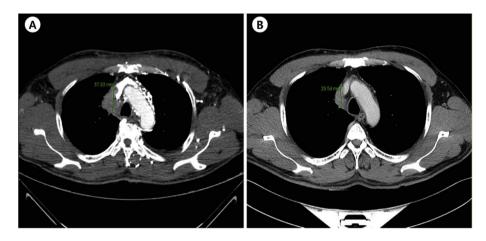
Initial lung mass in chest CT scan (A), and follow up chest CT shows interval decrease in size of the primary lung cancer (B).
